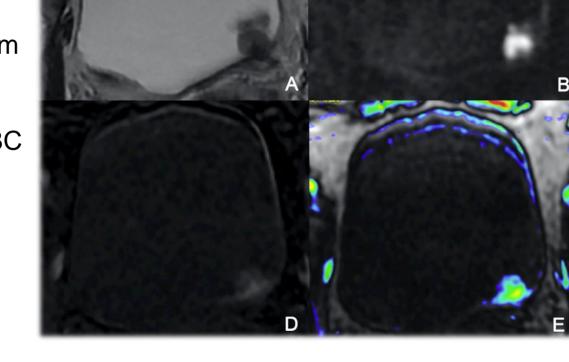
a) T2W imaging showed an exophytic lesion on the LL wall, > 1 cm in greatest dimension, with a low SI stalk. b) DWI (b = 2000) c) ADC map, showed an exophytic lesion with restricted diffusion
